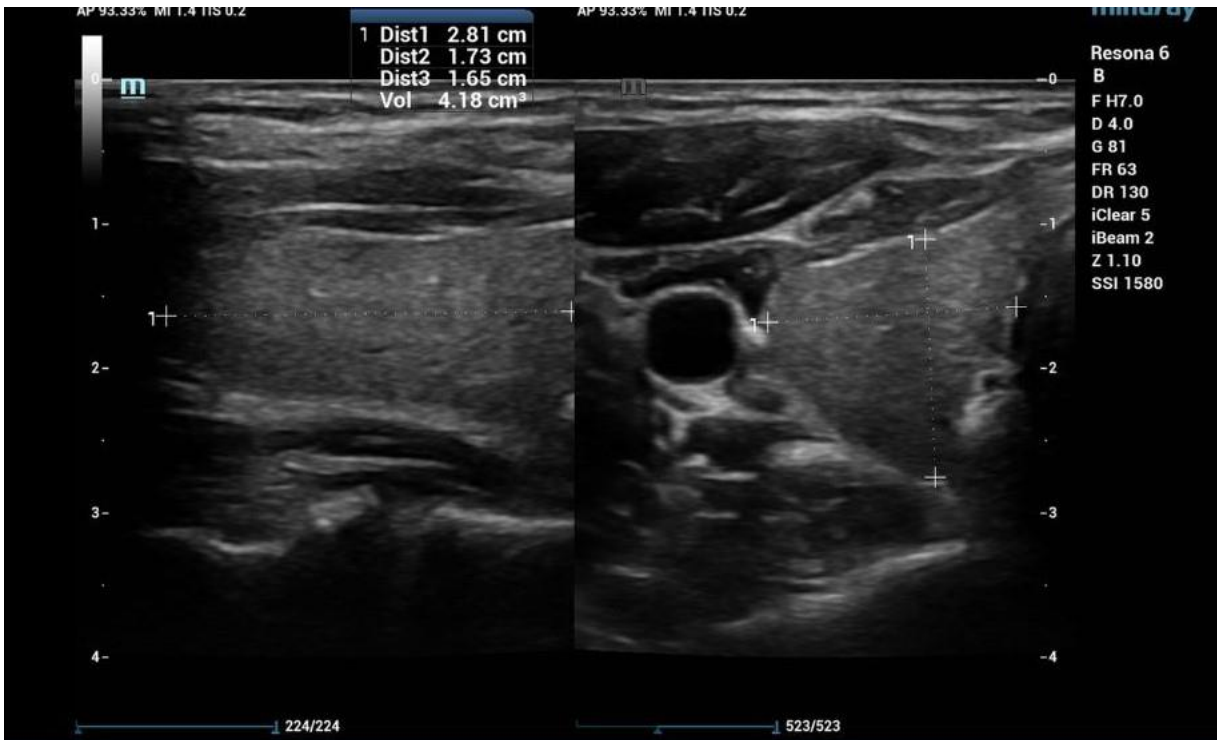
The ultrasound scan of the neck showing isoechoic nodule on the left lobe and bilaterally enlarged supraclavicular lymph nodes, larger on the left side with preserved fatty hilum and morphology.
